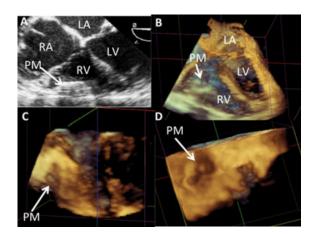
A pericardial mass was present in a patient with constrictive pericarditis. A. On a 2-dimensional (2D) transesophageal echocardiography four-chamber view, the pericardial mass is located on the free wall and is seen protruding into the right ventricle. B. On a 3D four-chamber view, the pericardial mass is protruding into the right ventricle as a donut shape structure with a thin apical cap. C. A three-dimensional (3D) image is focused on the pericardial mass of the right ventricular free wall. After cropping, a cavity can be seen inside the pericardial mass reaching the apical part of the mass. D. A 3D image of the pericardial mass from the surface of the right ventricular free wall shows a depression into the myocardium. RA = right atrium; LA = left atrium; RV = right ventricle; LV = left ventricle; PM = pericardial mass.
